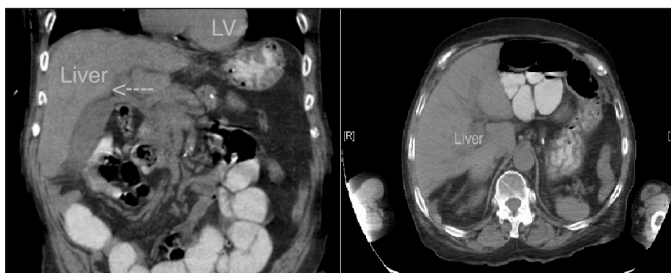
Longitudinal and cross-sectional abdominal CT showing gallstones in the biliary tract with normal position of the liver and gallbladder.
